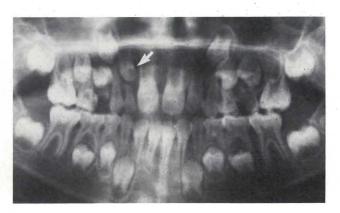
A panoramic radiograph of an 8.5-year-old male showing dens invaginatus of the right maxillary lateral incisor.
